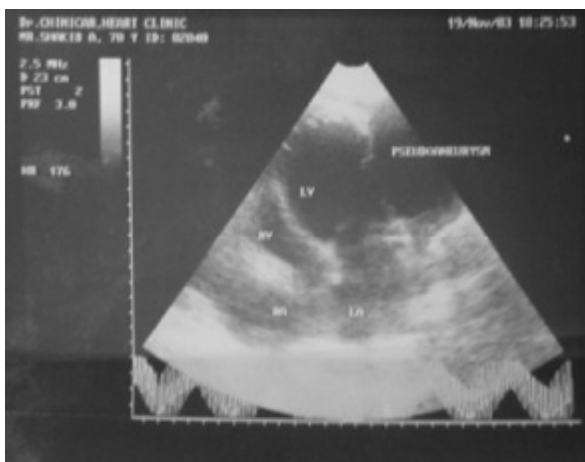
Four-chamber echocardiography view showing a large cavity attached to the lateral wall with a wide neck.
